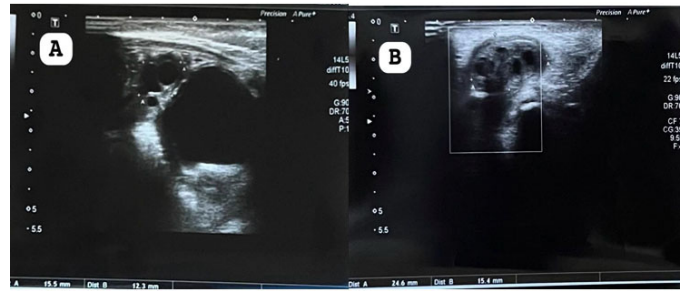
(A) Gray-scale ultrasound of the right ovary showing normal size, echogenicity, and follicular pattern. (B) Gray-scale and Doppler ultrasound of the left ovary demonstrating enlargement (24.6×15.4 mm), ovoid shape, heterogeneous echogenicity with multiple internal follicles, and absence of detectable vascularity.
